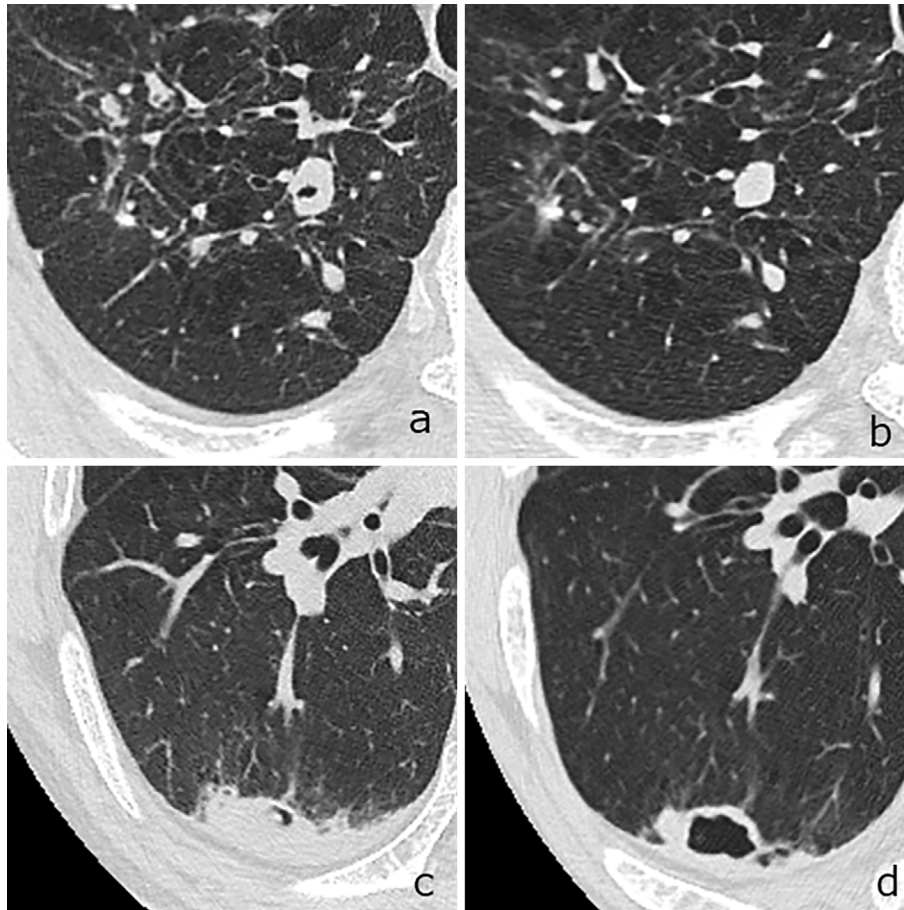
The computed tomography findings at the patient’s first visit (a, c) and six months after the initiation of antifungal therapy (b, d). One of the patient’s nodules decreased in size from 13 to 10 mm in diameter (a, b). The cavity wall of the right lower lobe lesion showed thinning (c, d).
